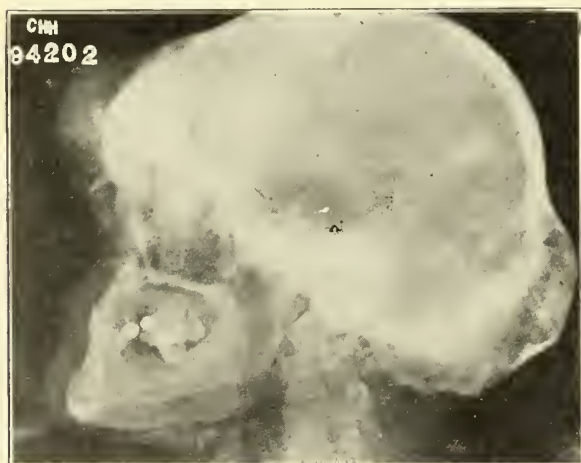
(Case A394202). Lateral roentgenogram revealing an osteosarcoma of the right frontal bone and an osteoma of the occipital bone.
